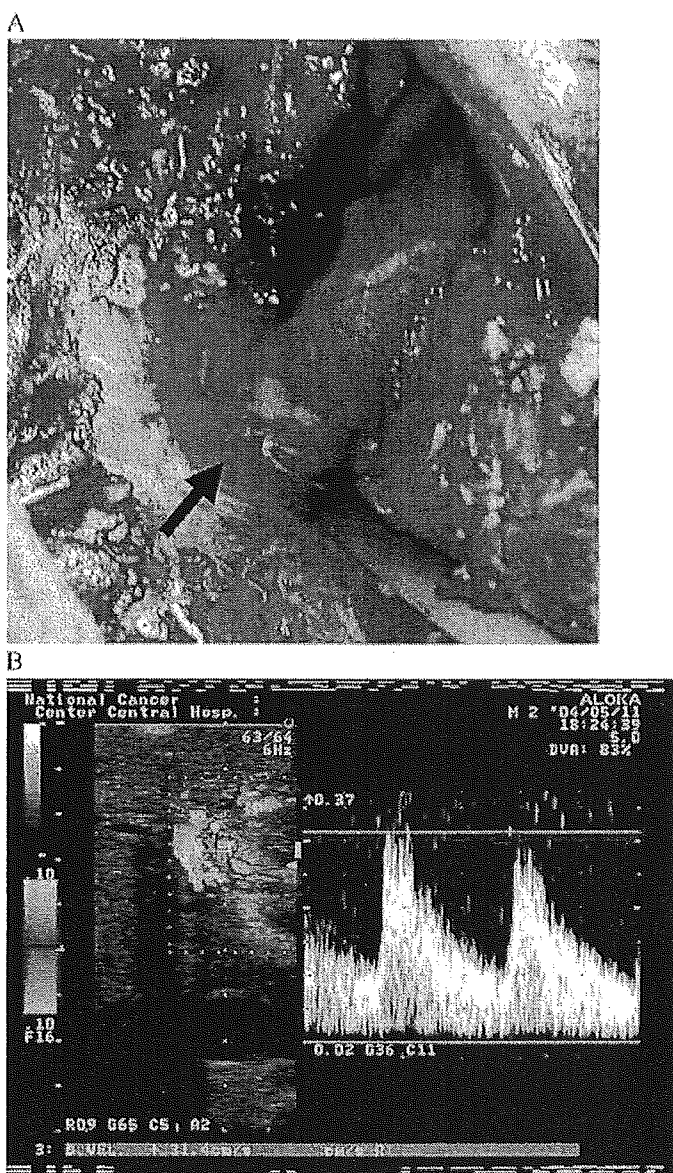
A. The root of celiac axis (arrow) is exposed. B. Doppler ultrasonography shows a dramatic increase in the intrahepatic arterial signal.
